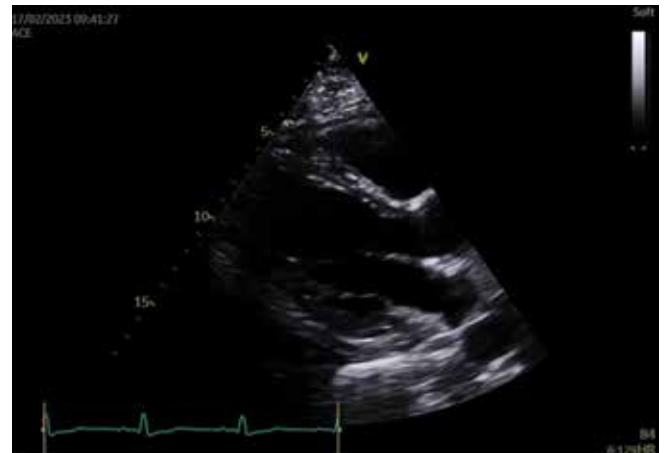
Long parasternal view of resolution of pericardial effusion after antibiotic treatment.
